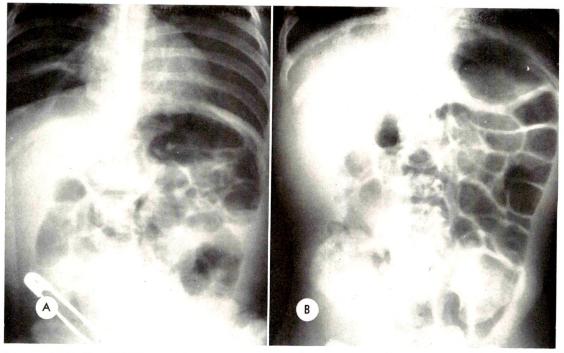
(A) Sitting and (B) recumbent roentgenograms of a very malnourished 5 month old male who had a large protuberant abdomen. Much gas is present in both small and large intestine. Note atelectasis of the middle lobe of the right lung in A. Following vigorous therapy directed at management of the respiratory and digestive systems, the boy gained rapidly from below the 3rd to the 90th percentile in height and weight.
